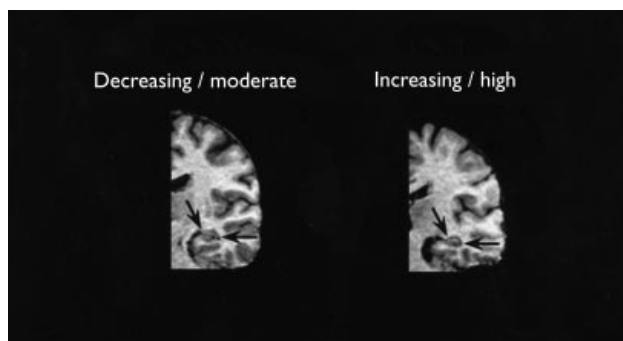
Reformatted (perpendicular to the long axis of the hippocampus) coronal T1-weighted gradient echo coronal MRI image of the hippocampus (arrows on left side) at the level of the lateral geniculate body for representative increasing/high and decreasing/moderate subjects.
